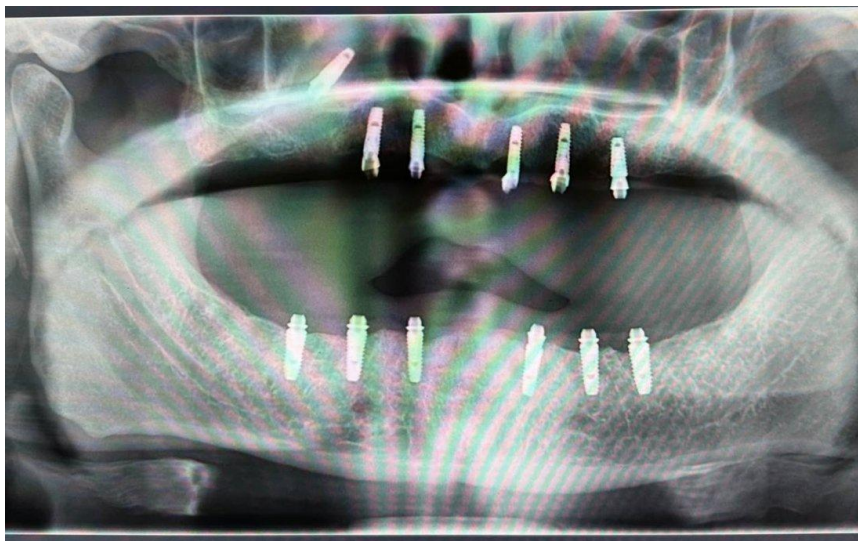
Panoramic radiograph showing the full-arch implant rehabilitation of the maxilla and mandible, with a radiopaque implant projected within the maxillary sinus above the standing maxillary implants.
